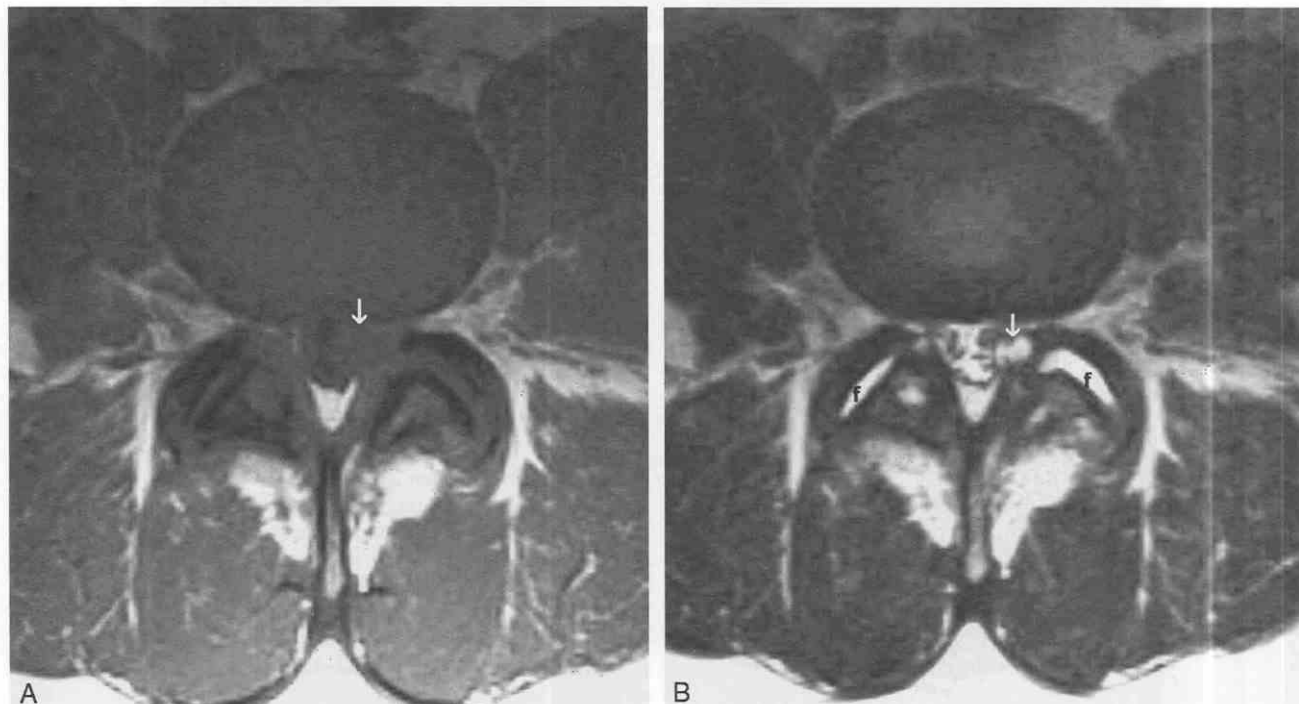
Synovial cyst. T1-weighted (A) and T2-weighted (B) images of a left synovial cyst (arrows). In this case, the synovial fluid is isointense to cerebrospinal fluid on both sequences. The cyst emanates from fluid (f) in the joint capsules.
